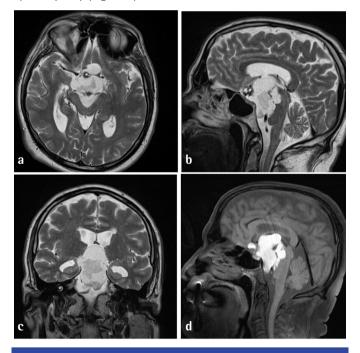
(a-c) Axial, sagittal, and coronal T2-weighted images. (d) Sagittal fat-saturated T1-weighted images demonstrate a large cystic mass in the parasellar region, which shows high signal intensity in all sequences
